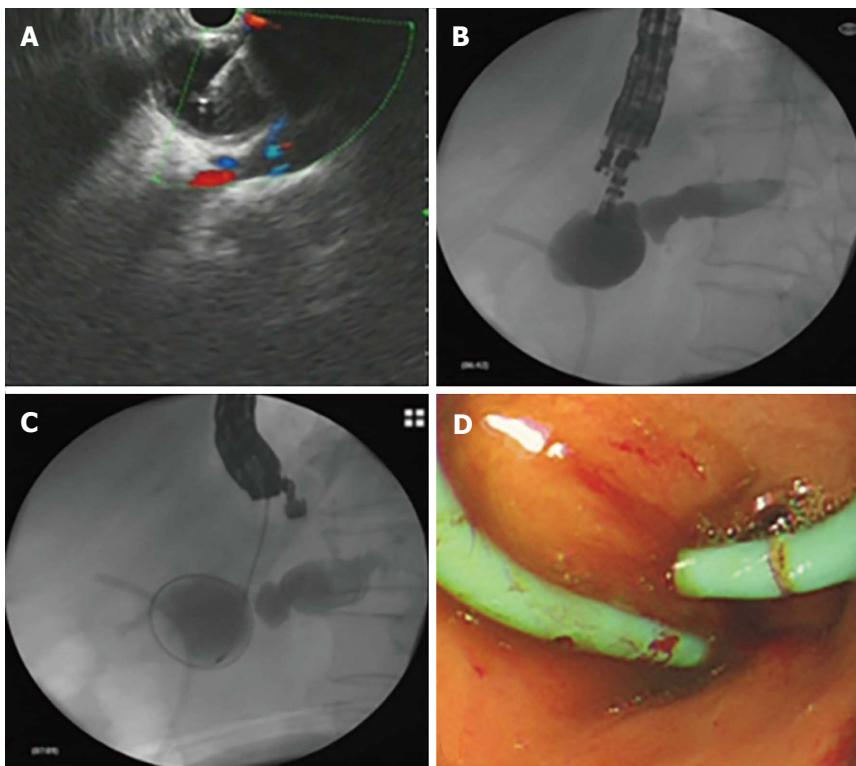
Endoscopic ultrasound-guided pancreaticogastrostomy. A: Endoscopic ultrasound-guided puncture; B and C: Contrast injection and cystotome advancement; D: Double pigtail stent placement.
